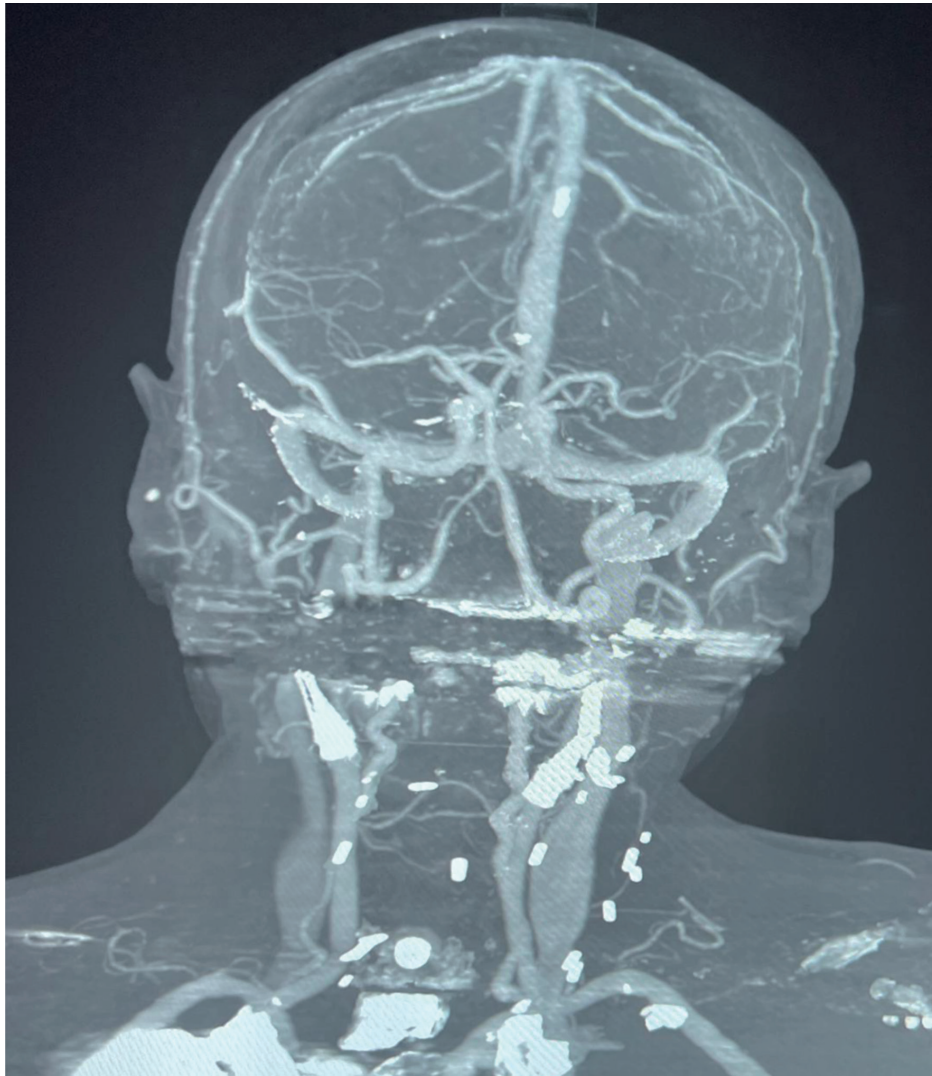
CT with contrast of the head. CT: computed tomography.
